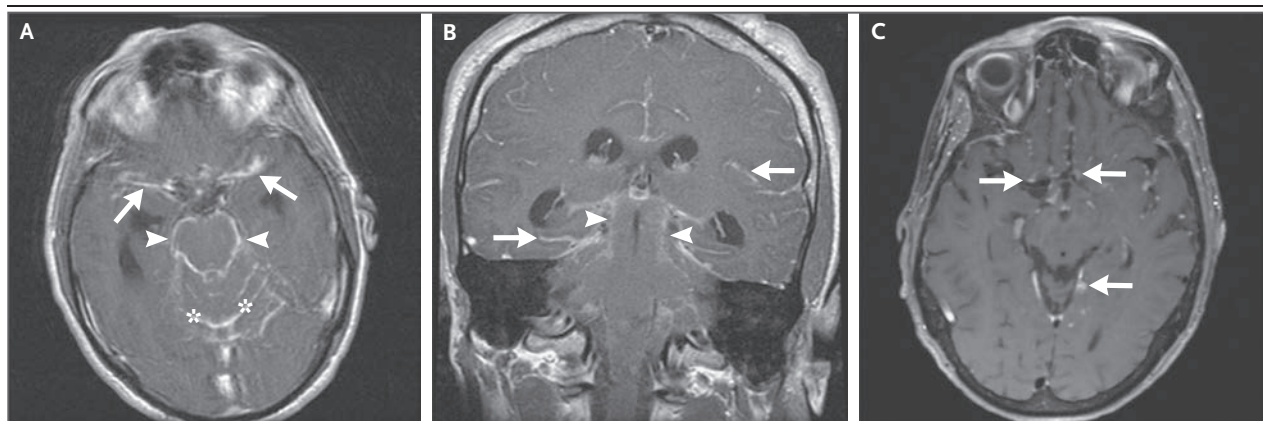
T1-Weighted MRI of the Head Showing Leptomeningeal Enhancement.
